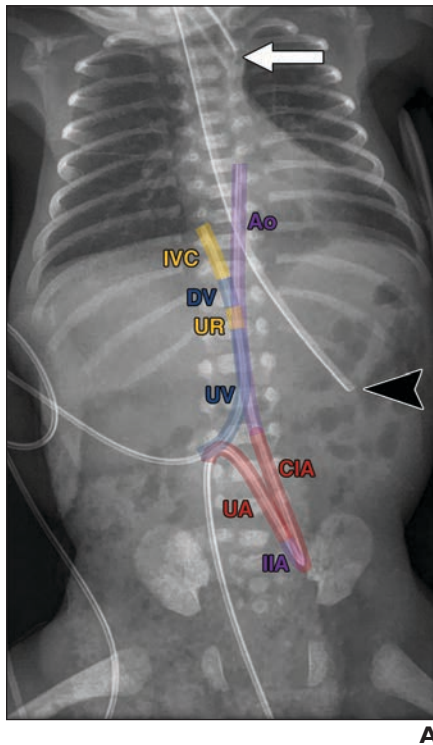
Appropriately positioned lines and tubes. A, 1-day-old boy born at 24 weeks' gestation. Frontal radiograph of chest and abdomen shows appropriately positioned endotracheal tube (arrow) with tip between clavicular heads and carina, umbilical artery catheter passing through umbilical artery (UA) to internal iliac artery (IIA) to common iliac artery (CIA) to aorta (Ao) with tip at level of T6, umbilical venous catheter passing through umbilical vein (UV) to umbilical recess (UR) to ductus venosus (DV) to inferior vena cava (IVC) with tip at inferior cavoatrial junction, and orogastric tube (arrowhead) with tip in stomach. B, 4-week-old boy. Frontal chest radiograph shows weighted nasoduodenal tube (white arrow) with tip in duodenum, nasogastric tube (black arrow) with tip in stomach, and endotracheal tube (arrowhead) with tip between clavicular heads and carina.
